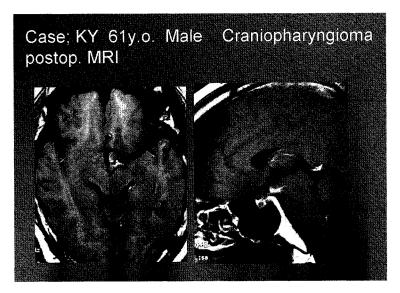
Postoperative MRI showing no residual tumor
